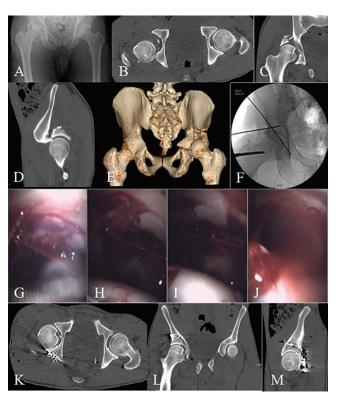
39-year-old male who fell from a ladder sustaining a right hip dislocation with a posterior wall fracture. Injury AP pelvis x-ray (A). Injury axial (B), coronal (C), sagittal (D), and 3D reconstruction (E) computed tomography images demonstrating a comminuted posterior wall fracture with intra-articular debris. Intra-operative fluoroscopy with schantz pin in the femoral neck for distraction and provisional reduction stabilized with k-wires. Intra-operative use of camera to aid in visualization and judgment of articular reduction as well as assure that no further intra-articular debris needs to be removed (G, H, I, J). Postoperative axial (K), coronal (L), and sagittal (M) computed tomography demonstrating adequate reduction and remaining debris confined to the fovea.
